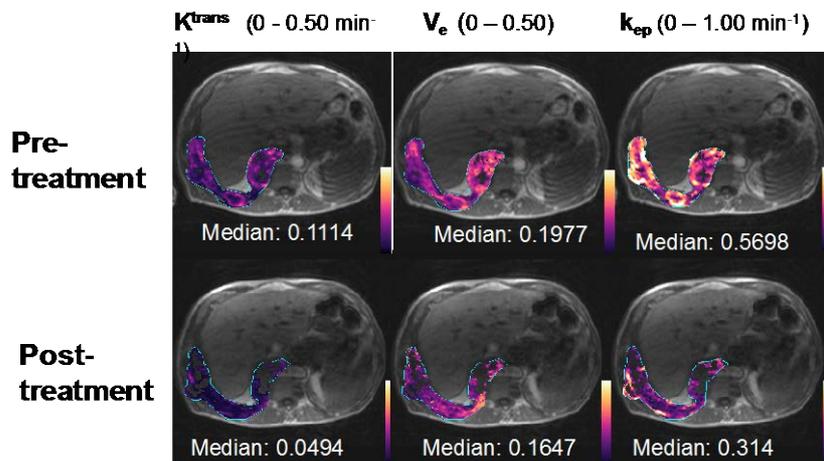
Dynamic contrast-enhanced MRI performed before and after treatment with a novel therapeutic in a patient with malignant mesothelioma.
